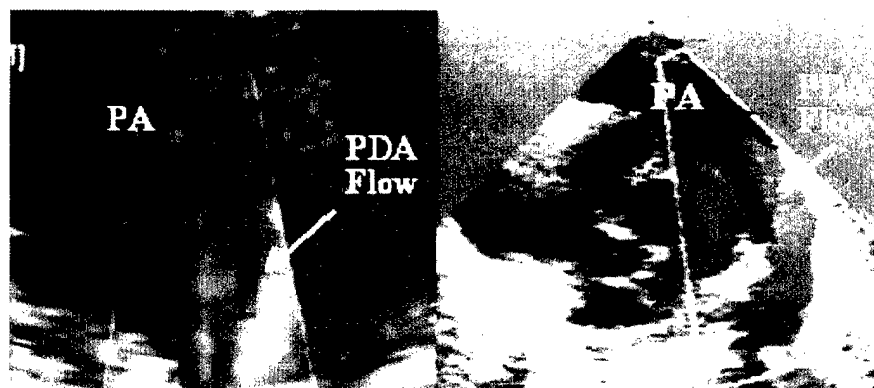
Color flow of patent ductus arteriosus (PDA) imaged with handheld system directional (power Doppler nonvelocity) map (*left*) compared with that imaged with full-feature system velocity color Doppler (*right*).
